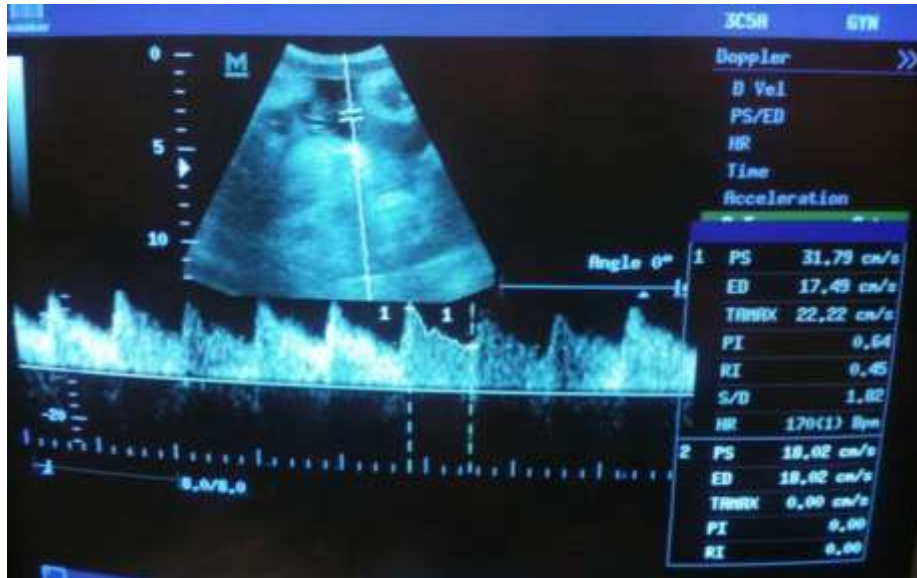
a) shows color Doppler umbilical artery waveform at 37 WKs
